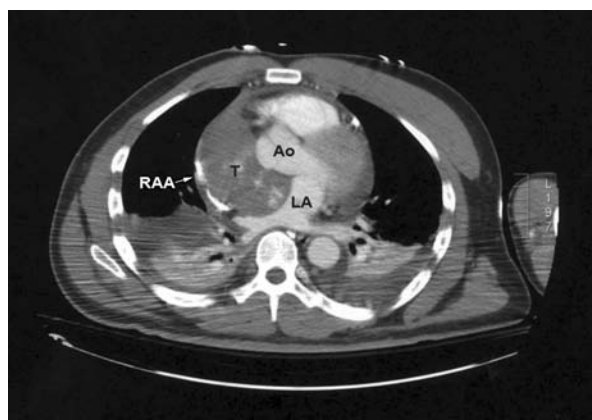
Contrast-enhanced axial computed tomographic scan shows a soft-tissue mass (8.6 × 4 × 7 cm) that extends rightward from the left atrium and compresses the right atrium.
